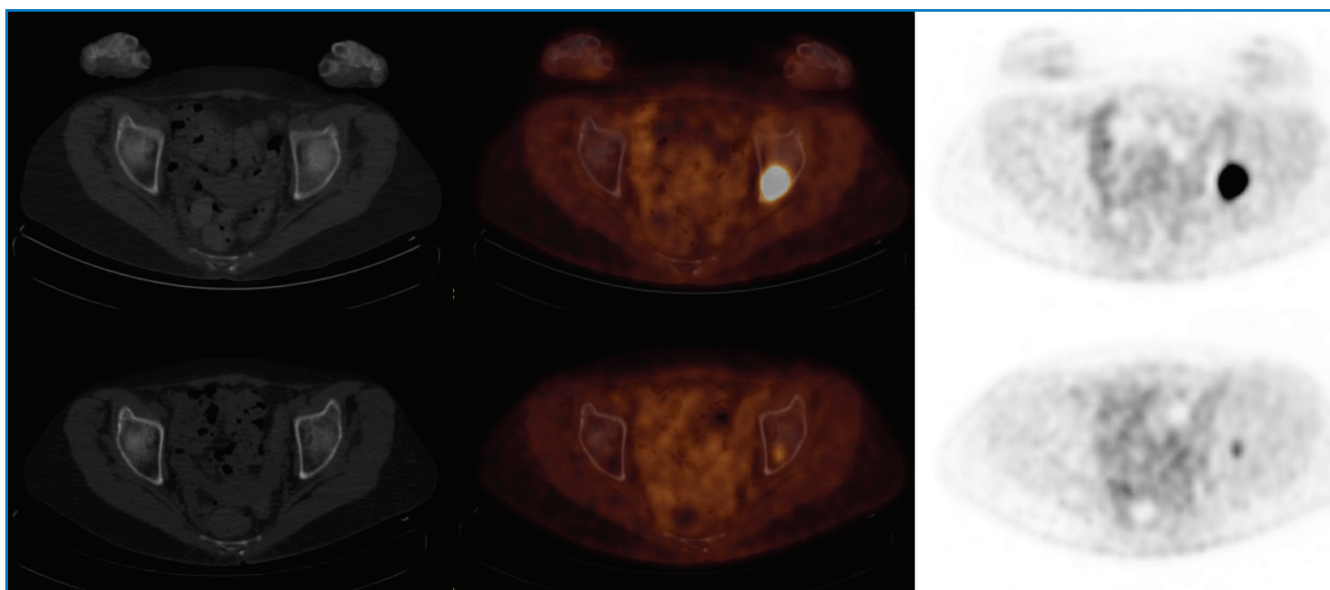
A follow-up PET/CT demonstrates significantly increased size and FDG uptake in the left acetabular lesion (top row) as compared to the prior study (bottom row).
